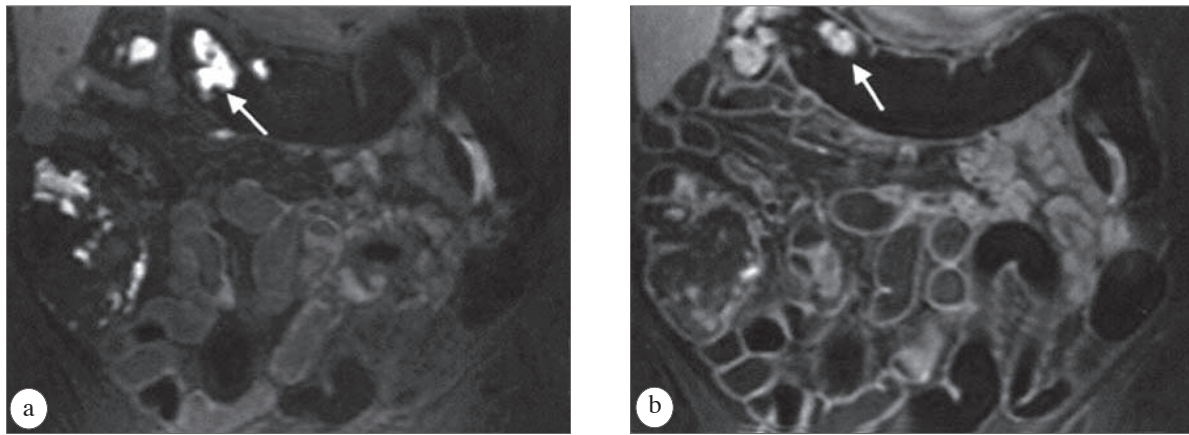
Dark-lumen magnetic resonance colonography. Tap water is used for bowel distension. a) A native coronal T1-weighted 3D VIBE sequence. b) The bowel wall is bright due to intravenous application of paramagnetic contrast. Residual stool (arrow) appears bright on pre- and post-contrast phases, and shows no contrast enhancement.
